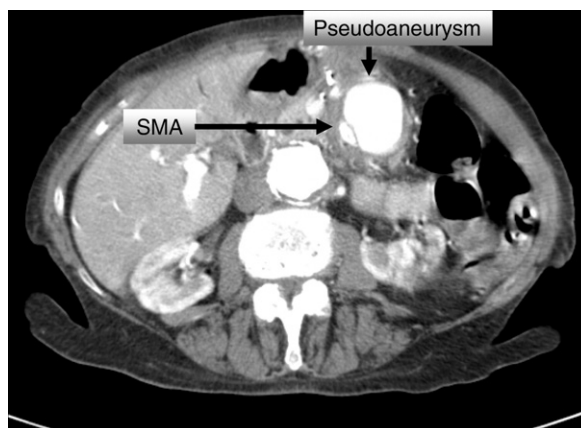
The initial abdominal computed tomography scan shows a pseudoaneurysm (*arrow*) of the superior mesenteric artery (SMA) that recurred in a 79-year-old woman 7 months after a previous open SMA pseudoaneurysm repair.
